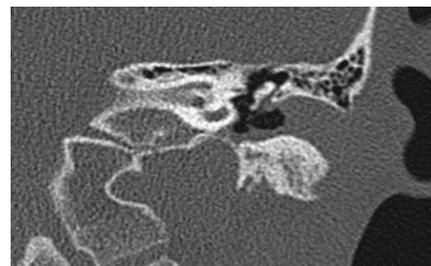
Left temporal CT corona-cut scan showed soft tissue filling the external auditory canal in a diabetic patient with Grade I (pinching) malignant otitis externa. Thickened tympanic membrane
